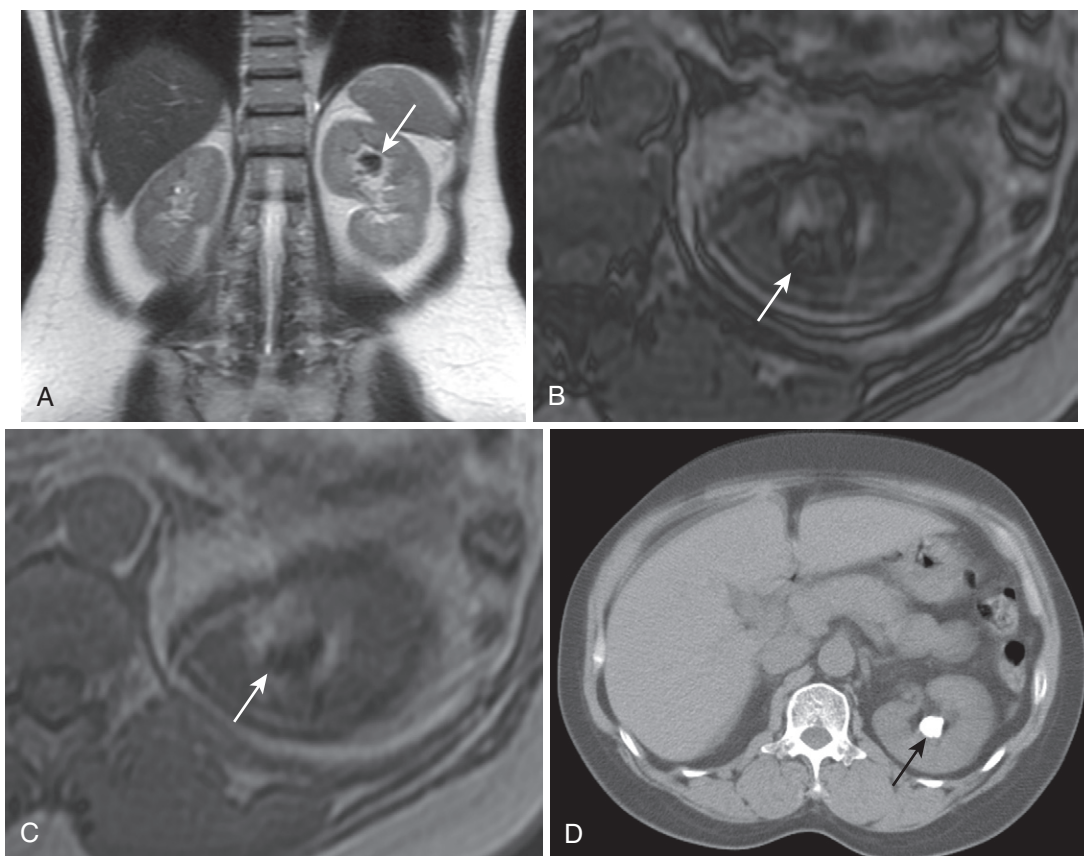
Renal calculi. A, The coronal heavily T2-weighted image demonstrates a signal void in the collecting system of the upper pole of the left kidney (arrow). Vague hypointensity (arrow in B) on the corresponding out-of-phase image (B), degraded by motion, blooms on the in-phase image (arrow in C) due to susceptibility artifact, induced by the presence of calcium, as seen on the corresponding computed tomography (CT) image (arrow in D).
